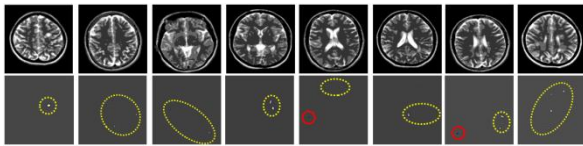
How to extract plaques from the middle eight slices of the MR image of a 47-year-old female patient with MS
